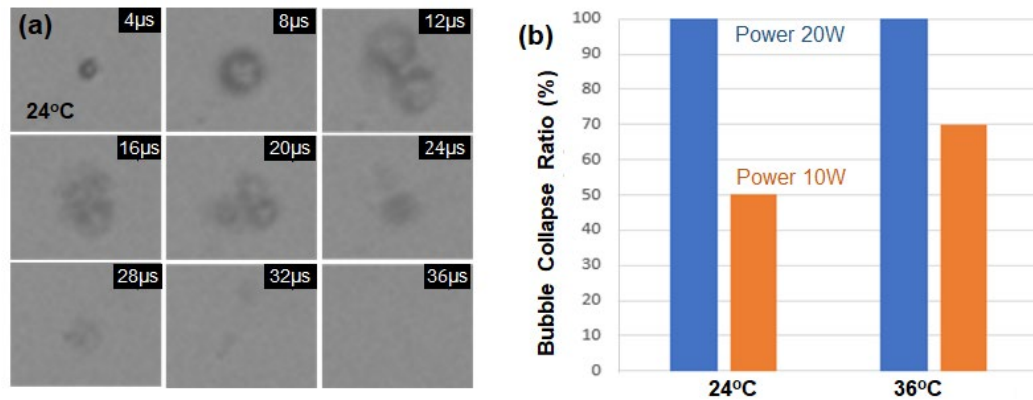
(a) The timeline images of a single droplet, excited by an ultrasound pulse of 1 μ s and power of 20 W at 24 °C. (b) The bubble collapse ratio depending on the acoustic power (10 W and 20 W) and the temperature (24 and 36 °C).
